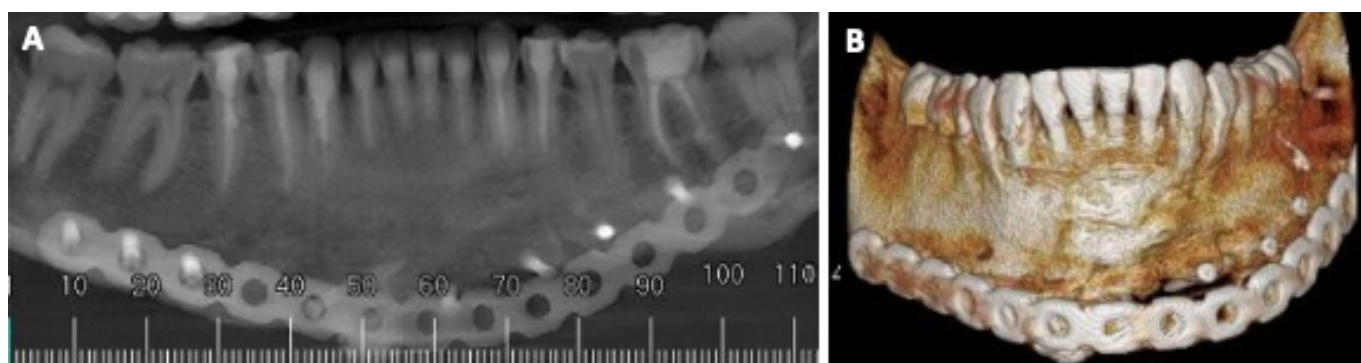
Immediate postoperative. A: Computed tomography showing adaptation of the plate and autogenous graft. B: Maintenance of the mandibular profile.
